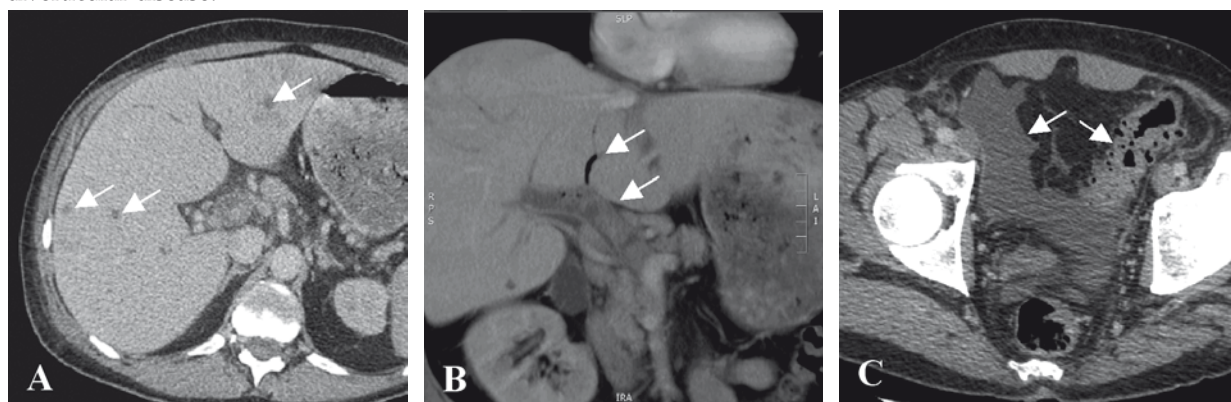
A – CT, axial plane, post-contrast series – multiple, hypodense irregular lesions in the liver parenchyma – septic hepatic abscesses; B – CT reconstructions, coronal plane, post-contrast series – hepatic portovenous gas and inhomogenous, hypodense mass in the lumen of portal vein – thrombosis; C – CT, axial plane, post-contrast series – thickened wall and diverticula of sigmoid colon, pelvic free fluid – confirming diagnosis diverticulitis
